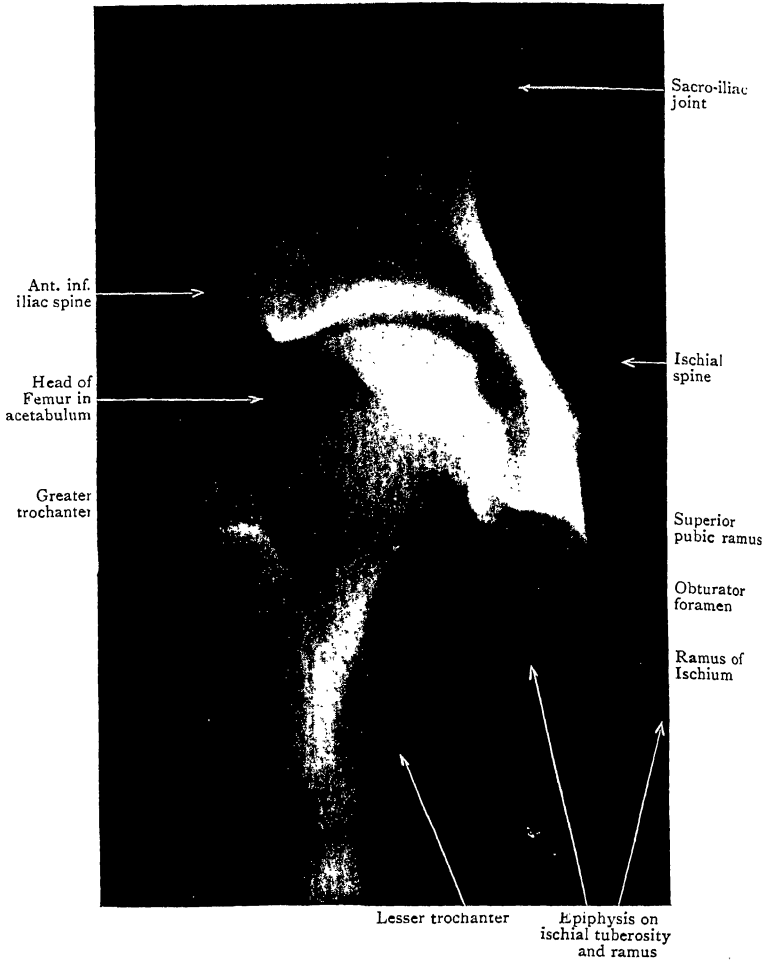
Radiograph of Hip of youth aged 17.
